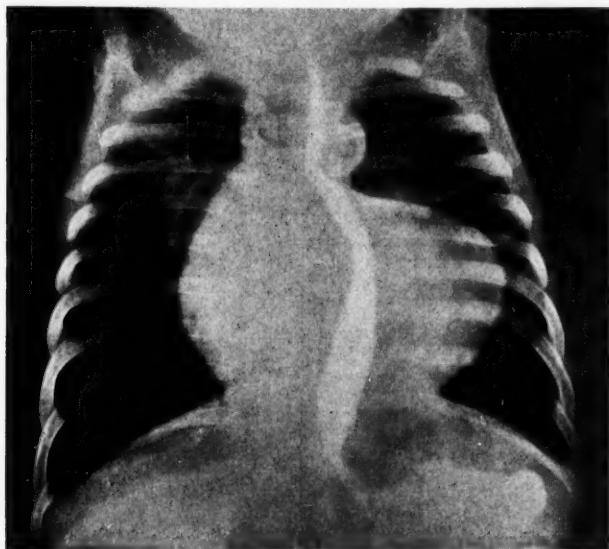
X-ray of heart of Case 1 in anteroposterior view.
